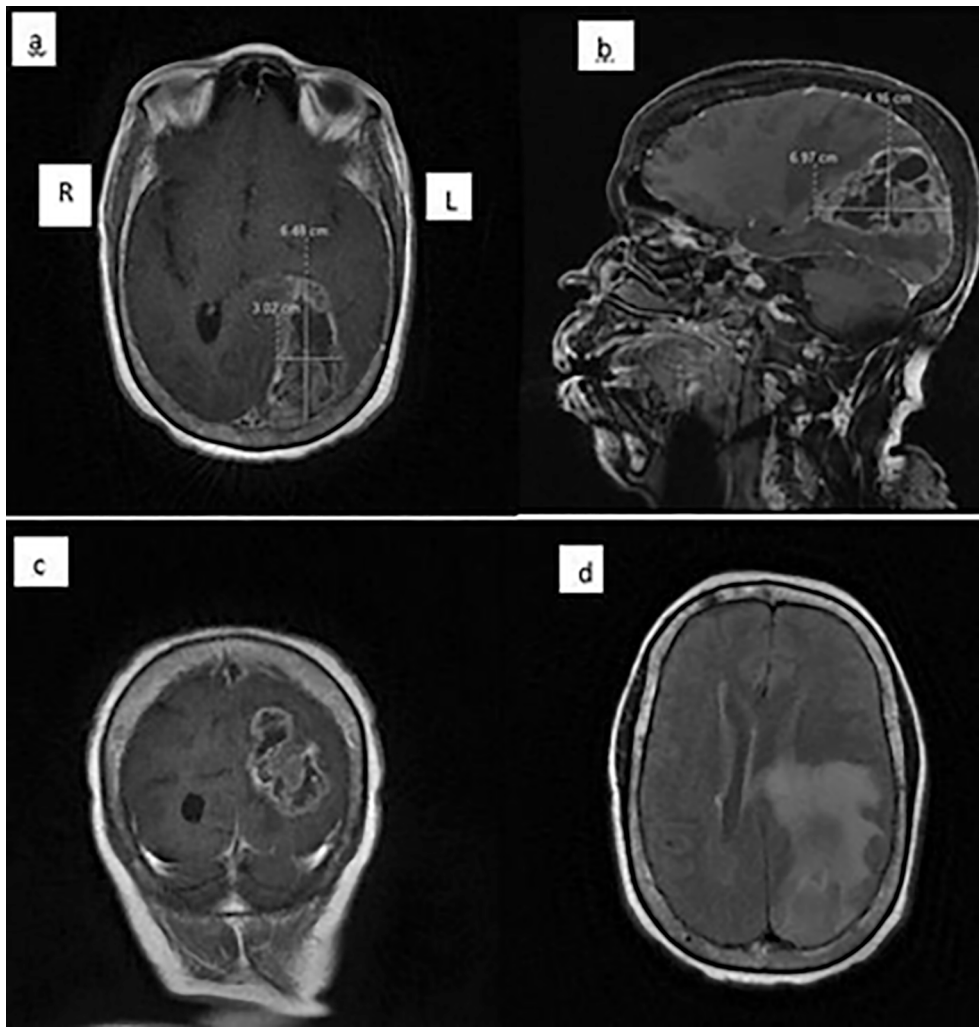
Pre-operative brain MRI; a. T1C axial image, b. T1C sagittal image c. T1C coronal image and d. FLAIR image.
